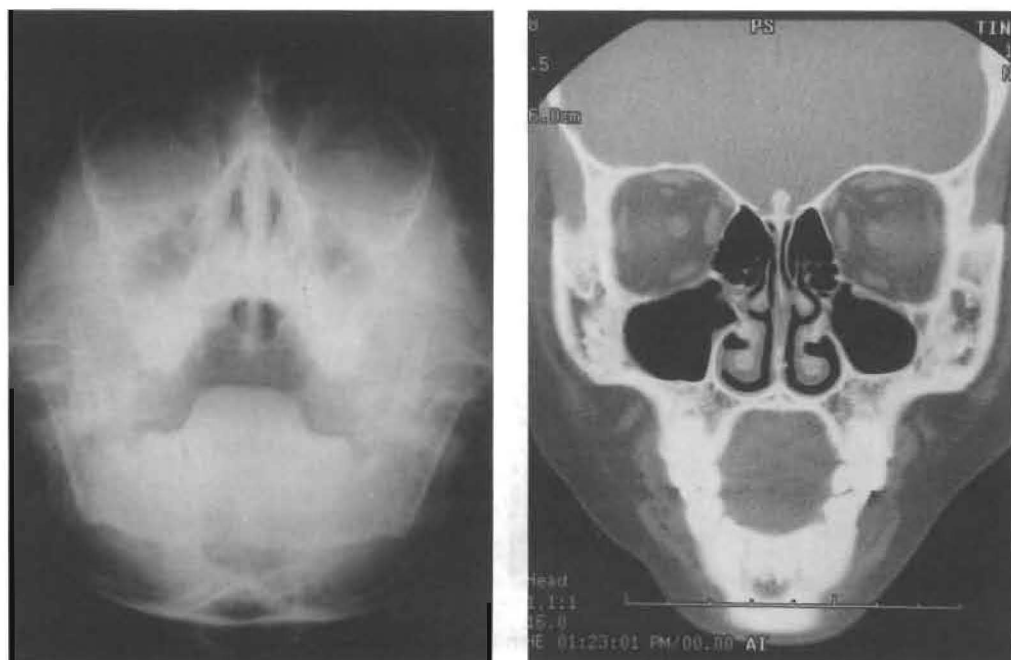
A: Waters' view of a 10 year-old boy shows mucosal thickening of maxillary sinuses; B: Representative CT scan is normal.
